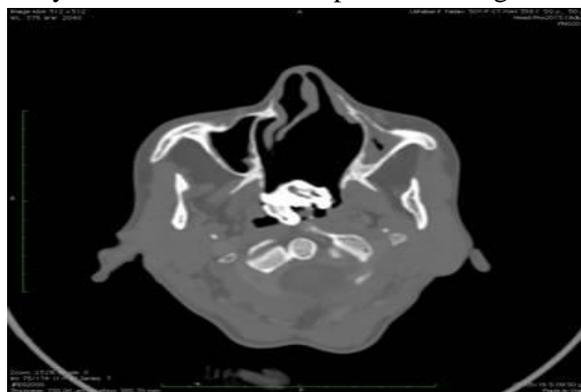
CT Scan shows a calcified foreign body with deviated nasal septum to the right side.
